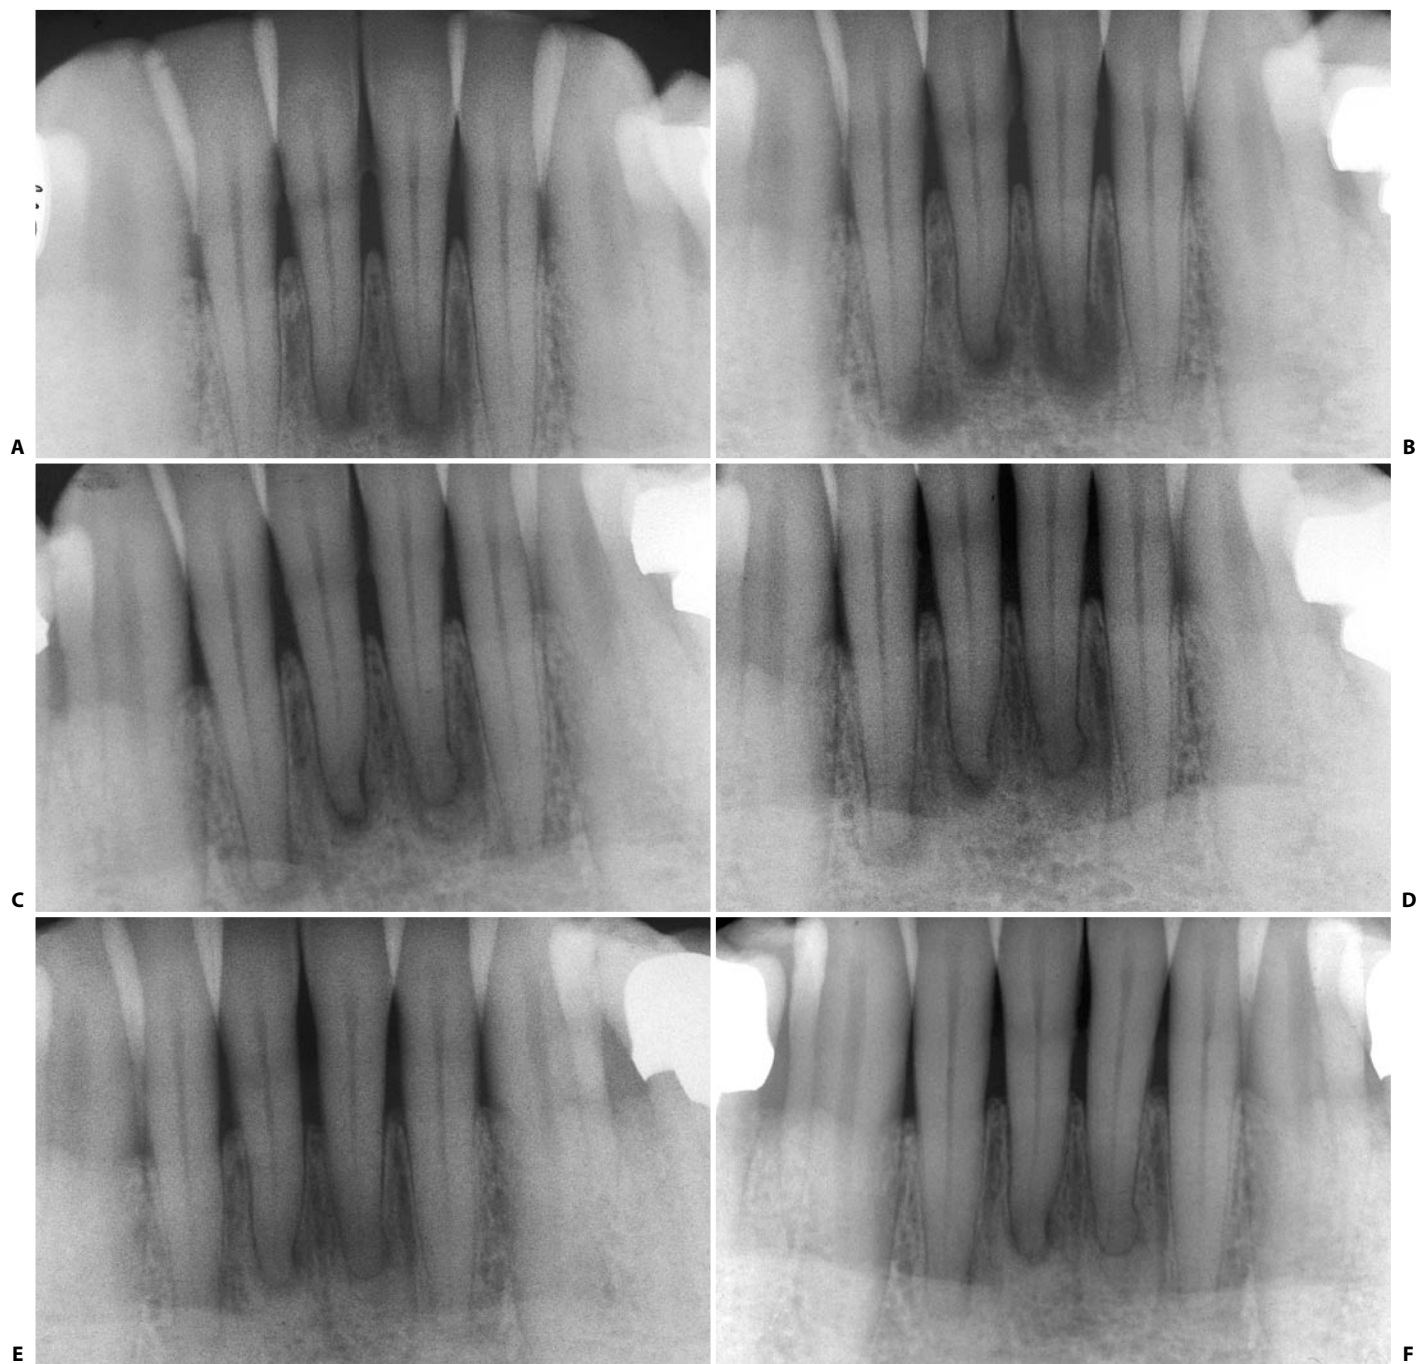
A. The lower central incisors of this 45-year-old patient present with a periapical radiolucency. The two teeth respond normally to the pulp tests and are not in occlusal trauma. This represents a case of periapical dysplasia of the cementum or periapical osteofibrosis in the osteolytic stage. These lesions need only be diagnosed and require no intervention. B. Four years later, the lesion is now also involving the right lateral incisor. C. Seven years later, the lesions are in the second stage, with initial calcification of the fibrotic tissue. The pulps continue to respond normally to the vitality tests. D. 12 year recall. E. 18 year recall. F. 20 year recall.
